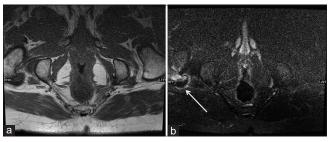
Patient presenting with right back pain and stiffness that had magnetic resonance imaging of the spine and sacroiliac joints (SIJs). Axial oblique T1 (a) and short tau inversion time inversion recovery (b) sequences demonstrate the right greater trochanter enthesitis (white arrow) at the gluteal medius insertion. This case highlights the importance of assessment of entheses at the edge of field in dedicated SIJ imaging. Confirmed MR stigmata of SpA were noted on the spinal and SIJ imaging.
